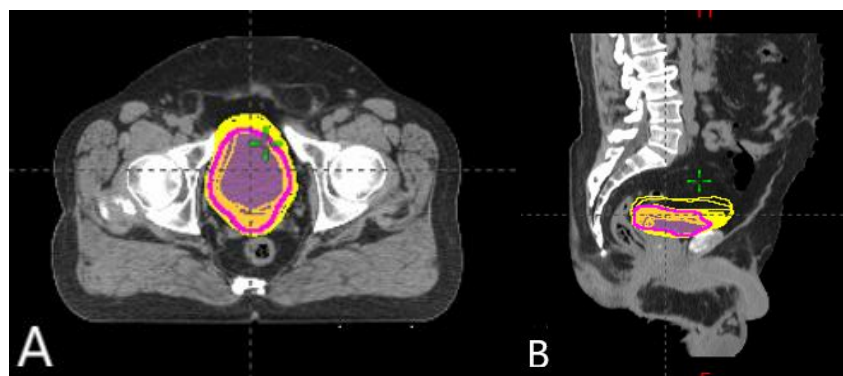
Reference delineated contour of bladder on CT scans (purple)
